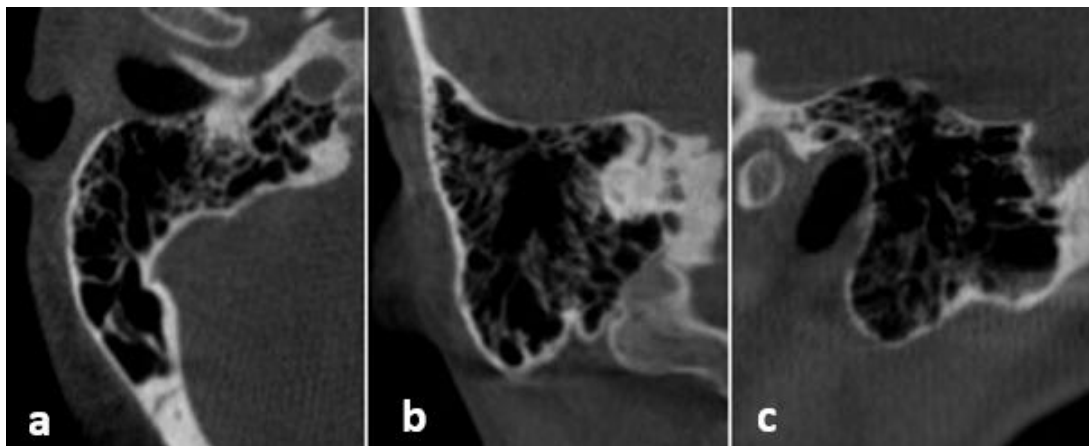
The images of CBCT of pneumatic mastoid process in axial (a), coronal (b) and sagittal (c) sections.
